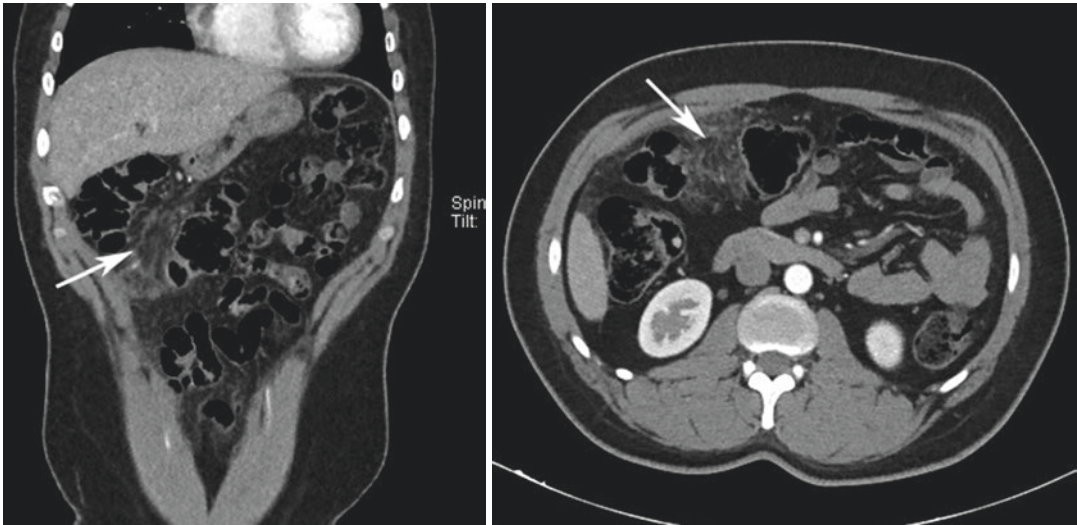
CT image of a patient with omental necrosis (Arrow) detected in the postoperative period
